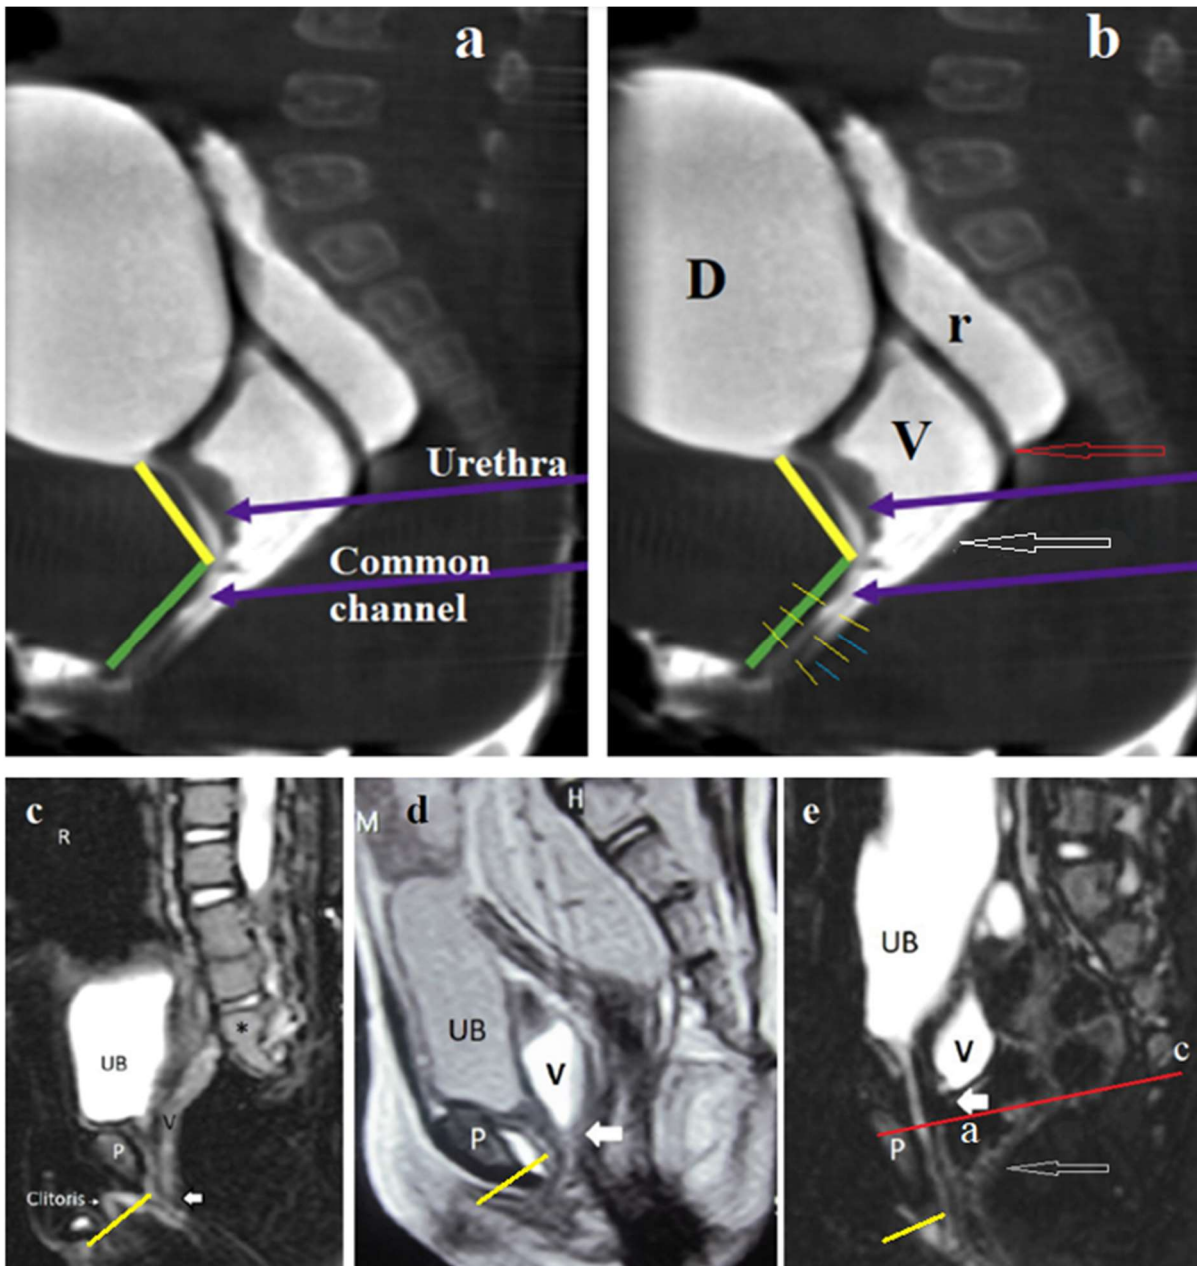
Radiographic anatomy of persistent cloaca. (a) MRI study from the article by Wood et al. [32], with the caption "Short common channel cloaca with adequate urethra." The authors suggest that, in the angle between the yellow and green lines, the urethra merges with the vagina to form a common channel. In the copy of the same image (b) I have shown the presence of two channels: between the yellow lines, you can see the continuation of the urethra up to the perineum, and next to it, the blue lines indicate the narrow vaginal canal. Between them, a dark dividing line can be observed, representing the fusion of the walls of the urethra and vagina. The upper part of the vagina (V) is dilated (hydrocolpos). The red arrow points to a rectum above the anal canal. The white arrow indicates at the site of the anal ectopy into the vagina. The contracted short anal canal is visible between the red and white arrows. The site of IAS
